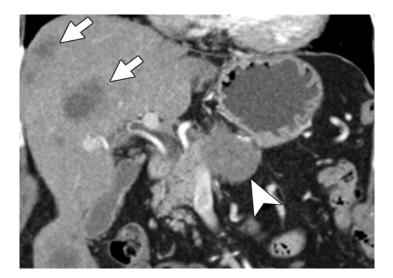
A CT scan of the same patient referred to in Figure 1 is obtained 12 months later. In this figure, PDAC symptoms had only begun to occur. By the time this CT scan was taken, metastasis (as shown by arrows) had already occurred, leaving the patient with unfavorable odds of survival. Should the CT scan shown in Figure 1 have been observed and interpreted correctly, PDAC would have been diagnosed earlier, giving the patient a better chance at survival
